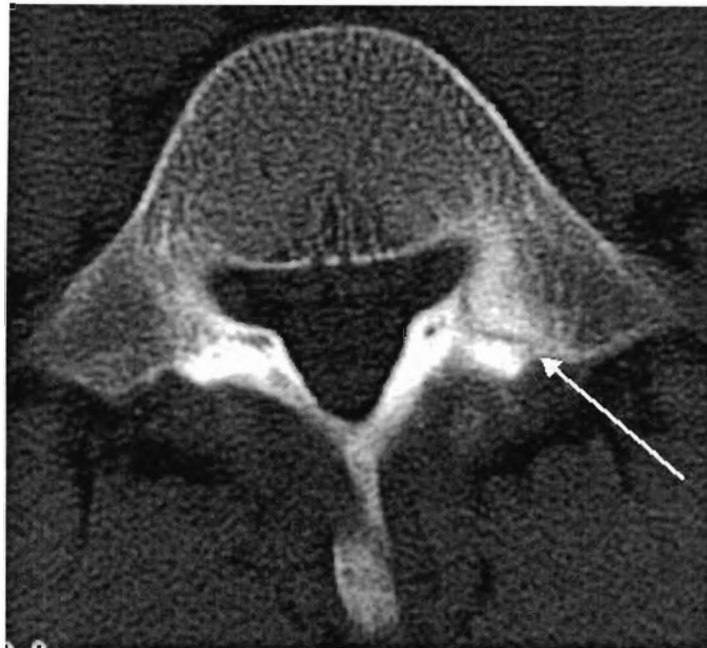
A CT scan of subject 2 (15-year-old right handed bowler) taken 3 months after the initial presentation of symptoms showing a partial healing of the left pars interarticularis stress fracture of lumbar 5 vertebra. The subject was free of pain 3 weeks after presentation of symptoms.
